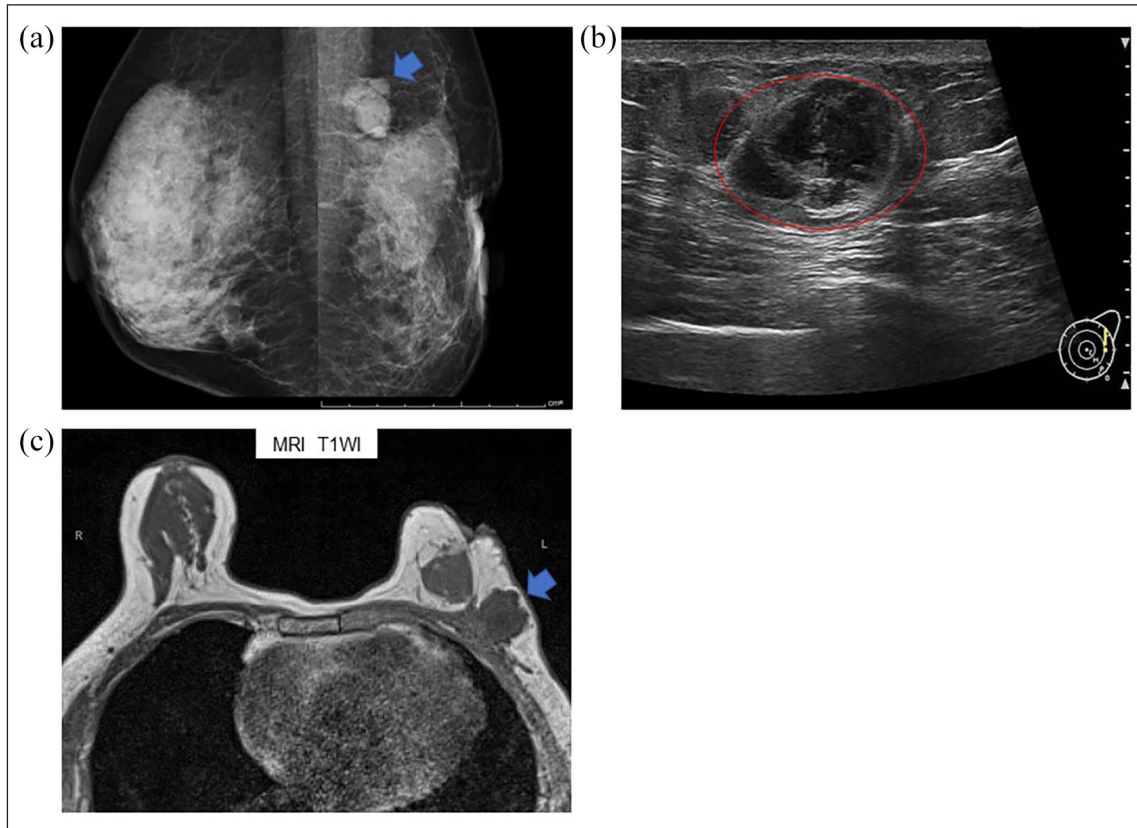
(a) Mammography showed a tumor shadow with a clear boundary in the outer upper quadrant of the left breast. (b) Breast sonography showed a lobulated hypoechoic tumor with a rough boundary. (c) MRI showed a 29-mm neoplastic lesion in the outer upper quadrant of the left breast.
